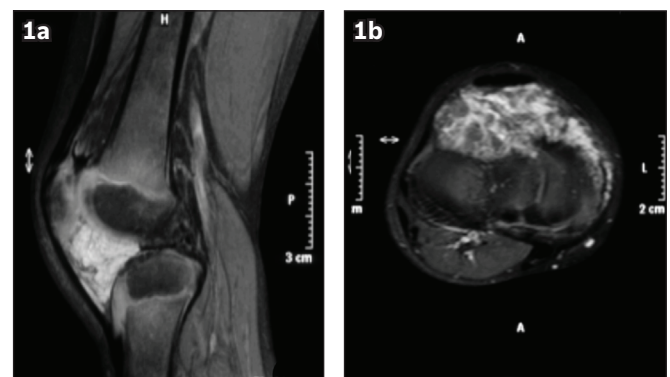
(a) Sagittal T2-W MR image shows a soft tissue mass over the infrapatellar region. (b) Cross-sectional T2-W MR image shows an intra-articular mass.
